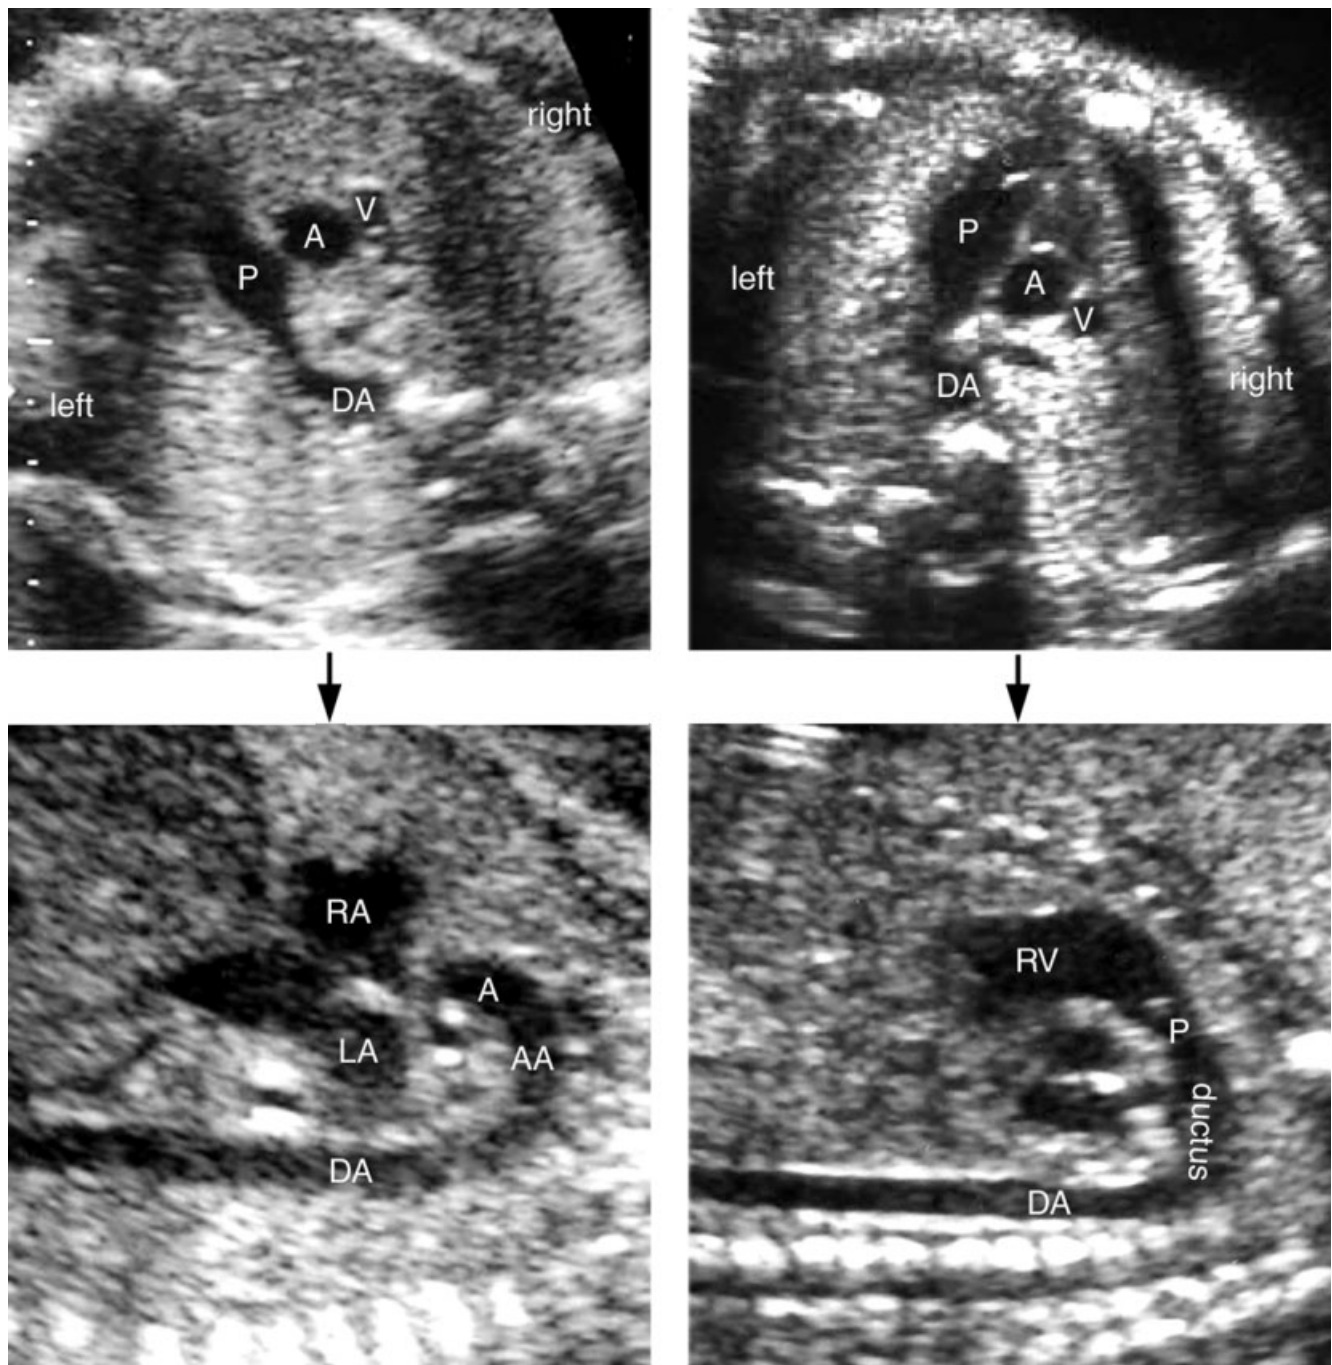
Maneuvers for visualization of the long-axis views of the aortic and ductal arches. For the aortic arch (AA), a three-vessel view is obtained so that the ascending aorta (A) and descending aorta (DA) are aligned vertically with the sonographic beam axis (left upper panel). Then the transducer is rotated 90°. The aortic arch is shown as a candy cane-shaped structure arising from the junction of the right (RA) and left (LA) atria (left lower panel). Note the head and neck branches of the aortic arch. For the ductal arch, a three-vessel view is obtained so that the main pulmonary artery (P) and descending aorta are aligned vertically with the sonographic beam axis (right upper panel). Then the transducer is rotated 90°. The ductal arch is shown as a hockey stick-shaped structure that is a continuation of the main pulmonary artery that arises from the right ventricle (RV). It does not give rise to any head and neck branches.
